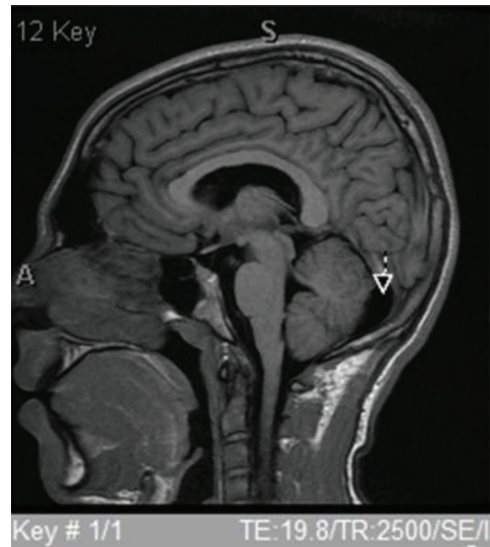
Sagittal T1 fluid-attenuated inversion recovery MRI without contrast showing a posterior fossa arachnoid cyst (PFAC; arrow)
